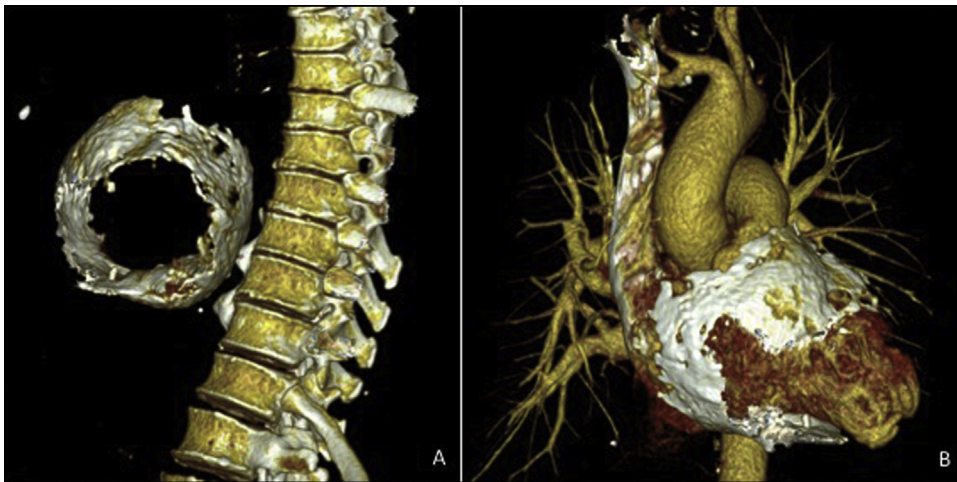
(A): Three-dimensional CT reconstruction showing extensive circumferential pericardial calcification (B): Three-dimensional CT reconstruction with soft-tissue extraction showing extensive circumferential pericardial calcification.
